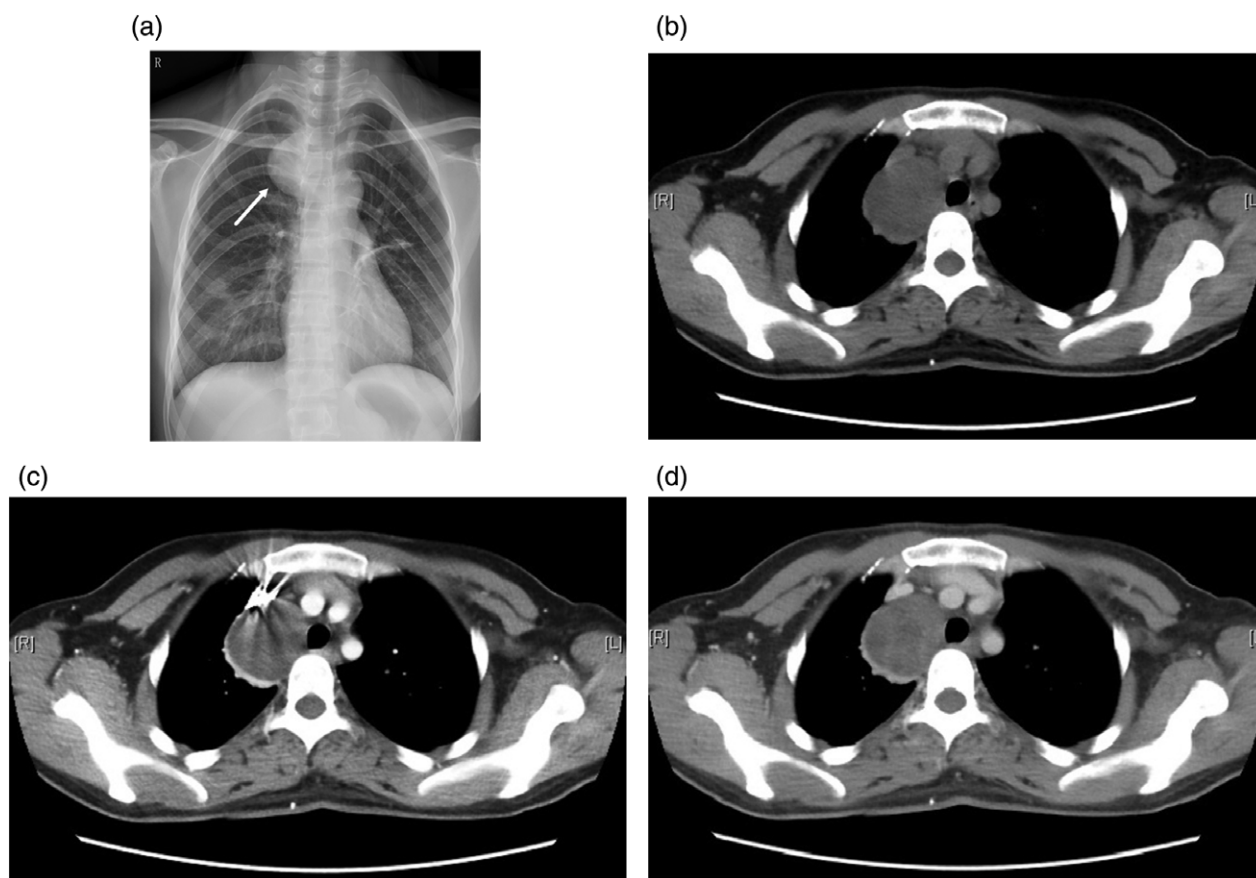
(a) Chest roentgenogram showed a right superior lung field mass protruding from the mediastinum (white arrow). (b) Computed tomography (CT) scan showed a clear boundary mass in the right superior mediastinum but no evidence of invasion into adjacent tissue. (c) The arterial phase of the contrast enhanced CT scan showed slightly heterogeneous enhancement of the tumor. (d) The venous phase showed a similar result.
